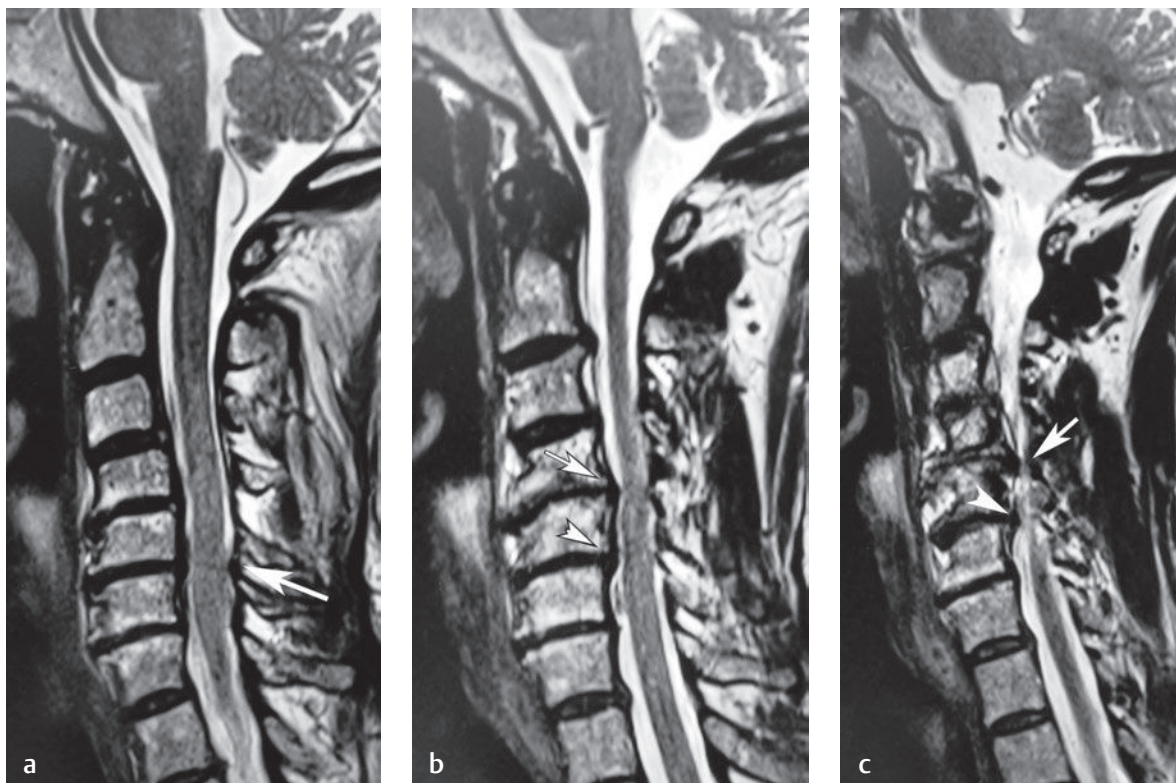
Cervical stenosis. (a) A midline sagittal T2-weighted image shows multilevel degenerative disc disease with mild spondylolisthesis at C3-C4 and thickening of the posterior longitudinal ligament at multiple levels. There is focal thickening of the ligamentum flavum at the C5-C6 level (*arrow*). (b) A parasagittal T2-weighted image obtained several millimeters lateral to the midline shows effacement of the ventral CSF space and moderate stenosis at the C4-C5 level (*arrow*) due to osteophyte formation and thickening of the posterior longitudinal ligament. Similar, but less severe, changes are seen at the C5-C6 level (*arrowhead*). (c) A parasagittal T2-weighted image obtained farther laterally in the plane of the neuroforamina shows severe foraminal stenosis at the C4-C5 level (*arrow*) and moderate foraminal stenosis at the C5-C6 level (*arrowhead*).[†]
